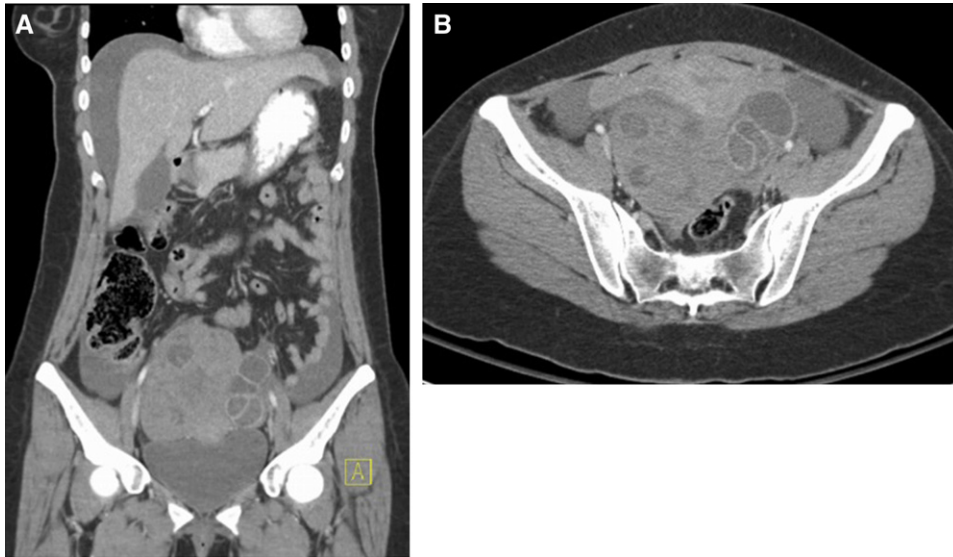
Ovarian hyperstimulation syndrome in a 29-year-old patient with right lower quadrant pain. (A) Coronal and (B) axial contrast-enhanced computed tomography, showing bilateral enlarged ovaries with multiple prominent follicles, left larger than right, as well as ascites. The uterus is displaced anteriorly.
